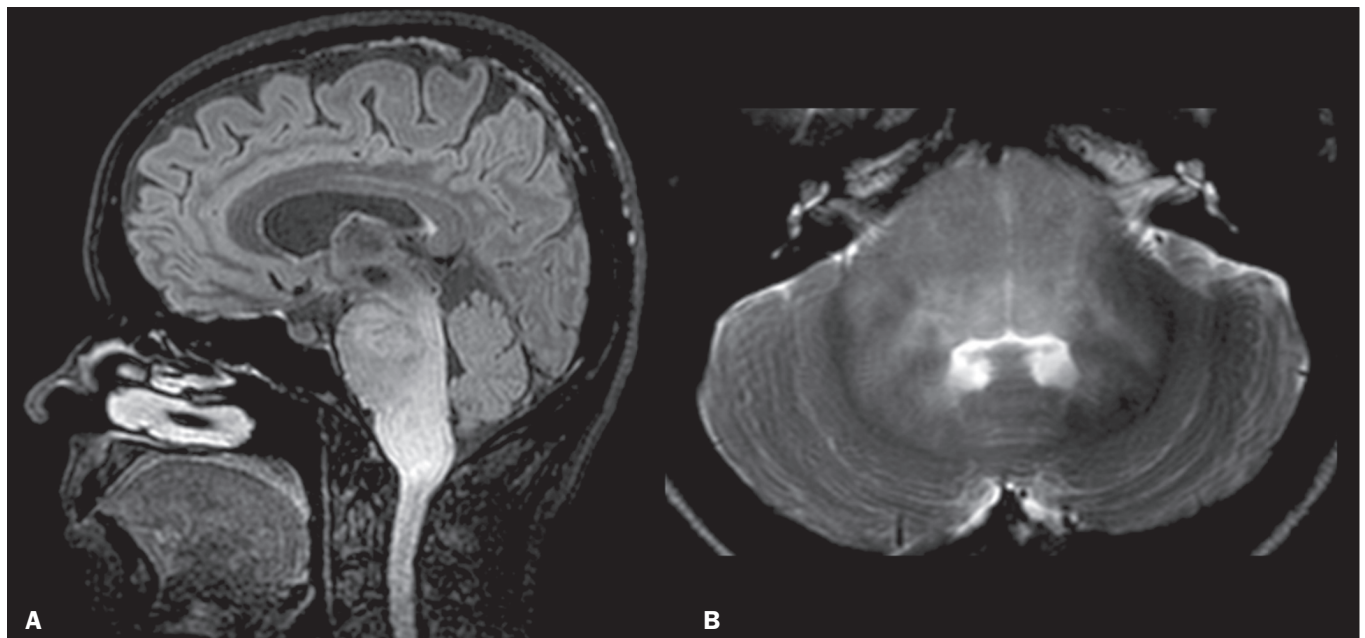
Diffuse midline H3K27M-mutated glioma. Sagittal FLAIR sequence (A) and axial T2WI (B), showing an expansile hyperintense lesion in the pons, and flattening of the fourth ventricle floor involving the medulla oblongata and the MCPs.
